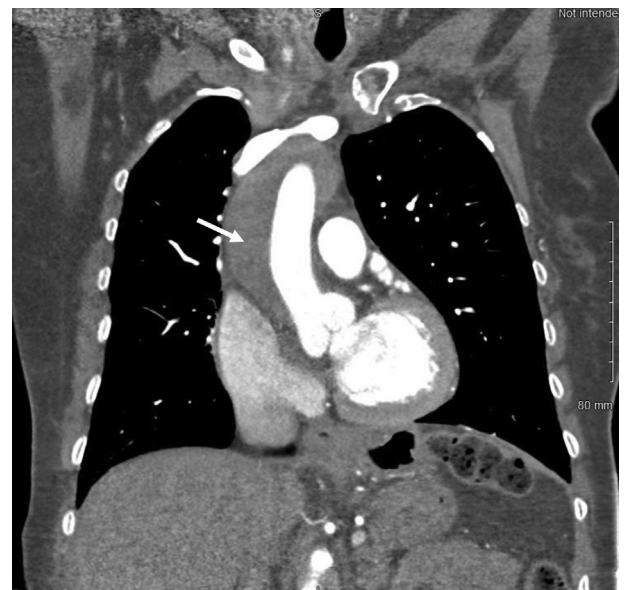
A computed tomography angiogram demonstrated a type A aortic dissection extending from the aortic root and involving the entire thoracic aorta (white arrow).
